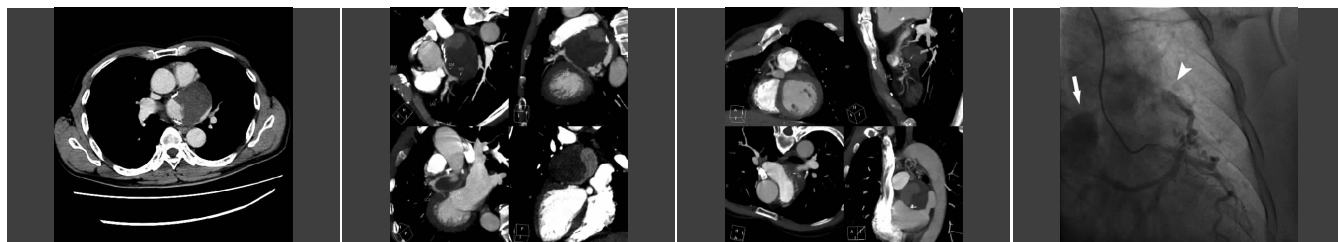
增强 CT 示病灶内团状明显 图 5 增强 CT 示病灶内强化区与冠状动脉左旋支-左房旋支远端相连 图 6 增强 CT 示冠状动脉(左、右远端膨大呈瘤样(箭头示), 左动脉圆锥支-肺动脉瘘(无尾箭头示)
